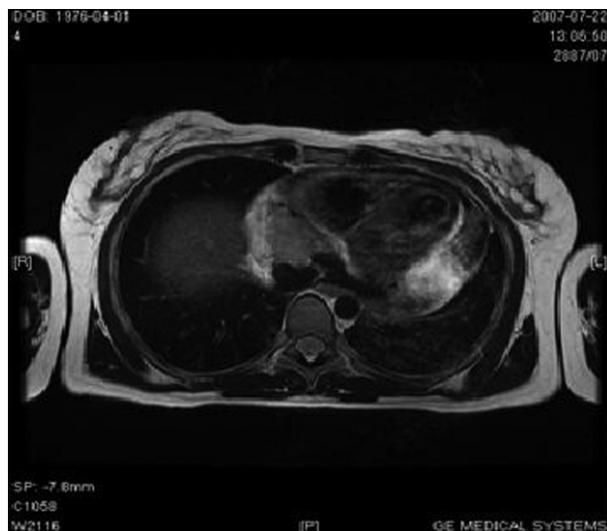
Magnetic resonance imaging scan. Visible polymorphic tumour (36 × 28 × 30 mm) located in the pericardial sac filled with fluid, located at the border of the inferior caval vein and right atrium
